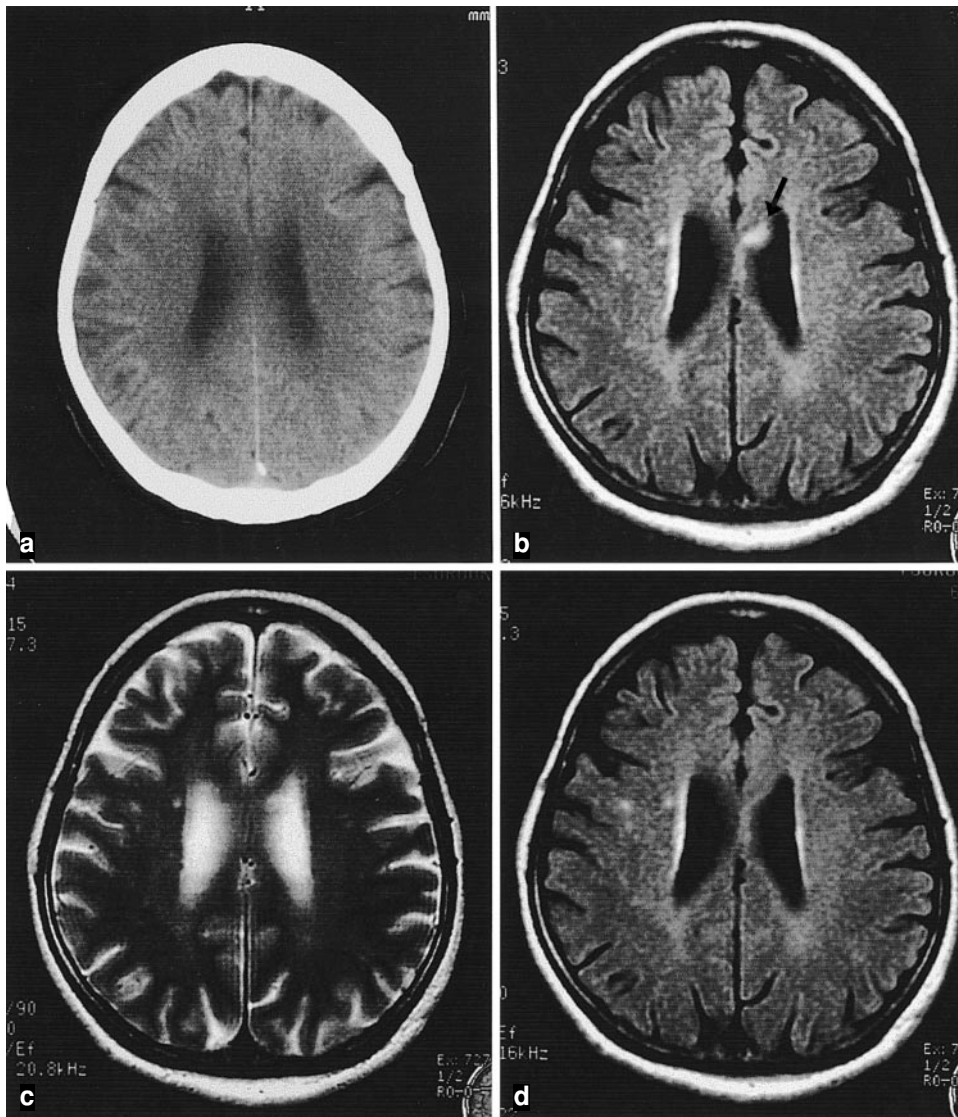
CT scan showed no abnormal findings (a). MR (FLAIR) imaging on Day 3 showed a small high signal lesion in the left lateral ventricle wall (arrow) (b). This lesion was not clear on T2 weighted imaging (c). It disappeared on FLAIR imaging at Day 30 (d)
